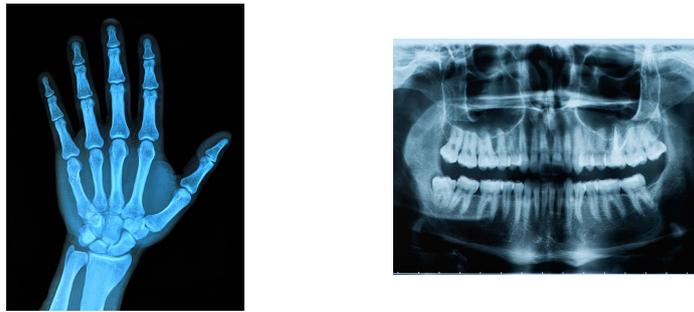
A radiograph of the left hand and wrist (on the left) and an OPG of the jaw (on the right). Photo: iStockphoto.com.
